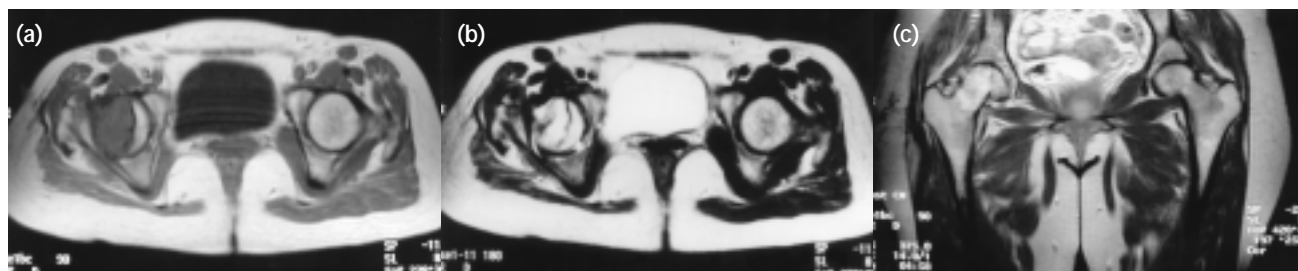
Magnetic resonance imaging showing (a) a mass in the anterolateral portion of the right femoral head with similar signal intensity to the surrounding muscles on axial T1-weighted image. Perforation of the cortex is also evident. (b) The mass has a hyperintense signal on axial T2-weighted image. (c) Coronal T1-weighted image after Gd-DTPA administration shows heterogeneous enhancement of the area affected by the tumour and a loss of cortical definition in the superolateral aspect of the femoral head.
